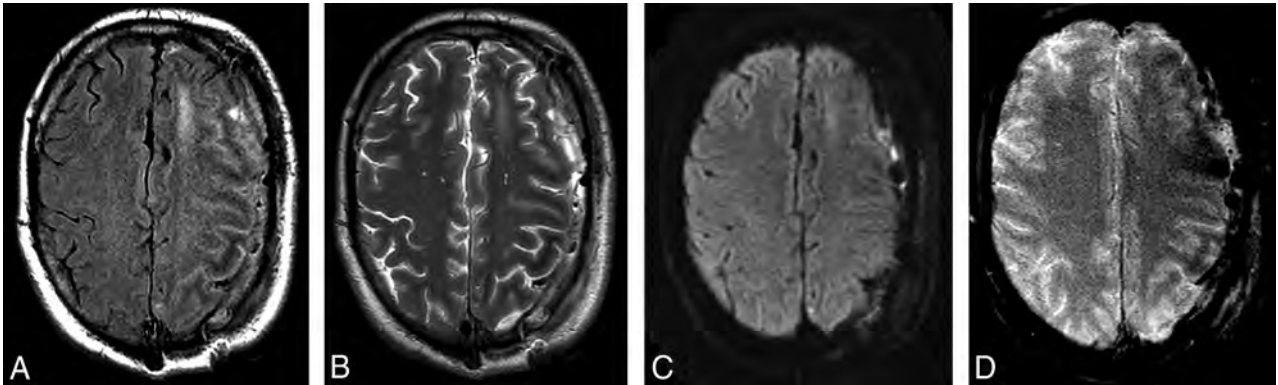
Patient admitted to the intensive care unit with persistent seizures 1 day after evacuation of a left-sided subdural hematoma. A, T2 FLAIR, B, FSE T2, C, DWI, and D, GRE-weighted images. Note the decreased T2-weighted signal in the subcortical white matter of the left frontal and parietal lobes on A and B, as well as the lack of corresponding diffusion restriction on C. D, GRE-weighted image shows there is subtle corresponding decreased subcortical white matter signal change.
